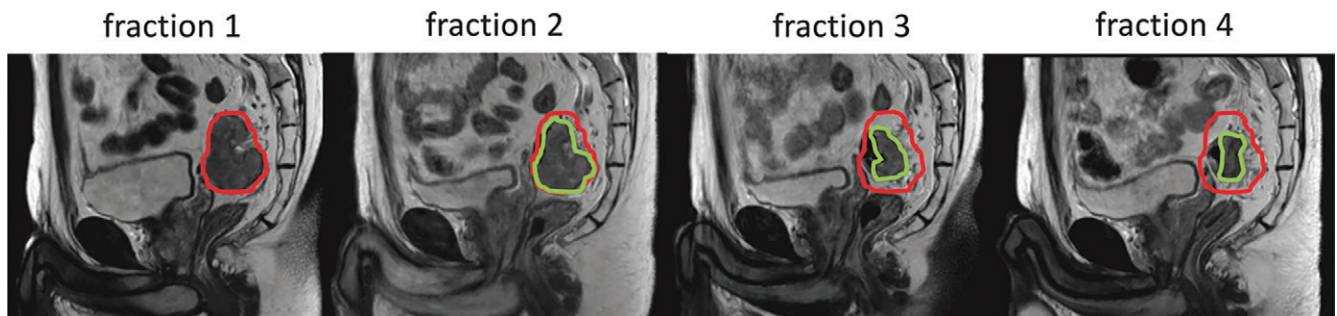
Interfraction adaptive treatment of a patient with rectal cancer on the Elekta 1.5T MRI-guided linear accelerator. Tumor contour for fraction 1 is shown in red and tumor contours for other fractions are shown in green. The ability to adapt treatment to the exact location and size of the tumor improved outcome and resulted in tumor remission. Figure adapted, with permission, from Drs Martijn In'tven and Bas Raaymakers, University Medical Center Utrecht.
